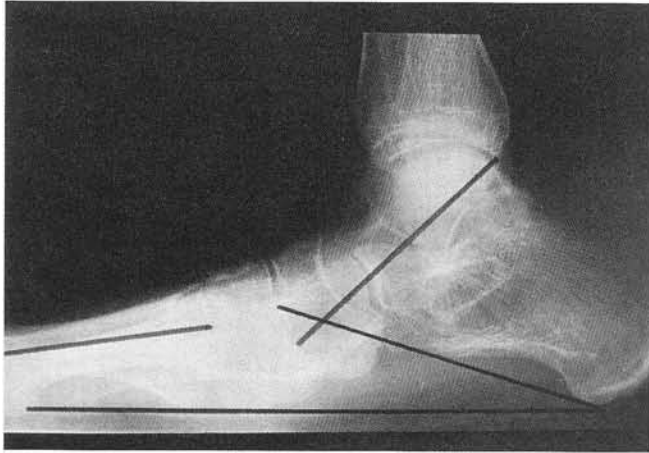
Lateral weight bearing radiograph. This view would suggest the need for a triple arthrodesis at the very least to achieve satisfactory restoration of alignment to the rearfoot and midfoot areas.
